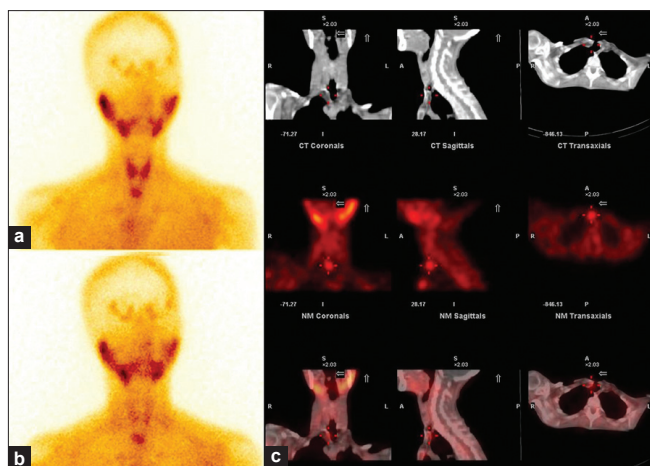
A 30-year-old female, case of pancreatitis, on workup was found to have raised serum calcium and PTH levels. USG neck was normal. (a) Early images of Tc99m sestamibi scan showed intense tracer uptake in the paratracheal region inferior to the thyroid gland along with uptake in both lobes of the thyroid gland. (b) Delayed images at 1 hour show focal retention of tracer in the paratracheal region with wash out from thyroid gland. (c) SPECT/CT imaging localizes the tracer uptake to the right paratracheal region inferior to thyroid gland superior to sterno-clavicular joint
